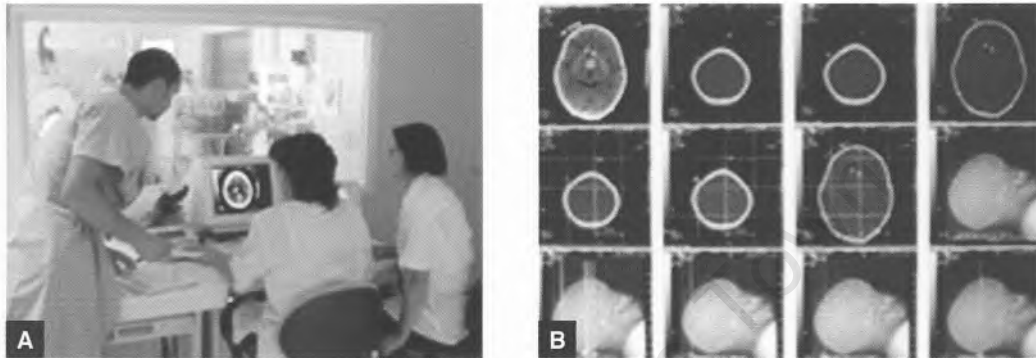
The CT control room for the RXH scanner; two radiographers are seated at the scanner console while Dr Tony Figaji selects the appropriate image (a). A series of images from this scanner showing the axial slices and the relevant surviws; the level at which each scan was taken is demonstrated by a line while the numerical value for the table position, and each X- and Y- co-ordinate for the selected target on the axial slices, is shown at the top right corner of the screen (b).
